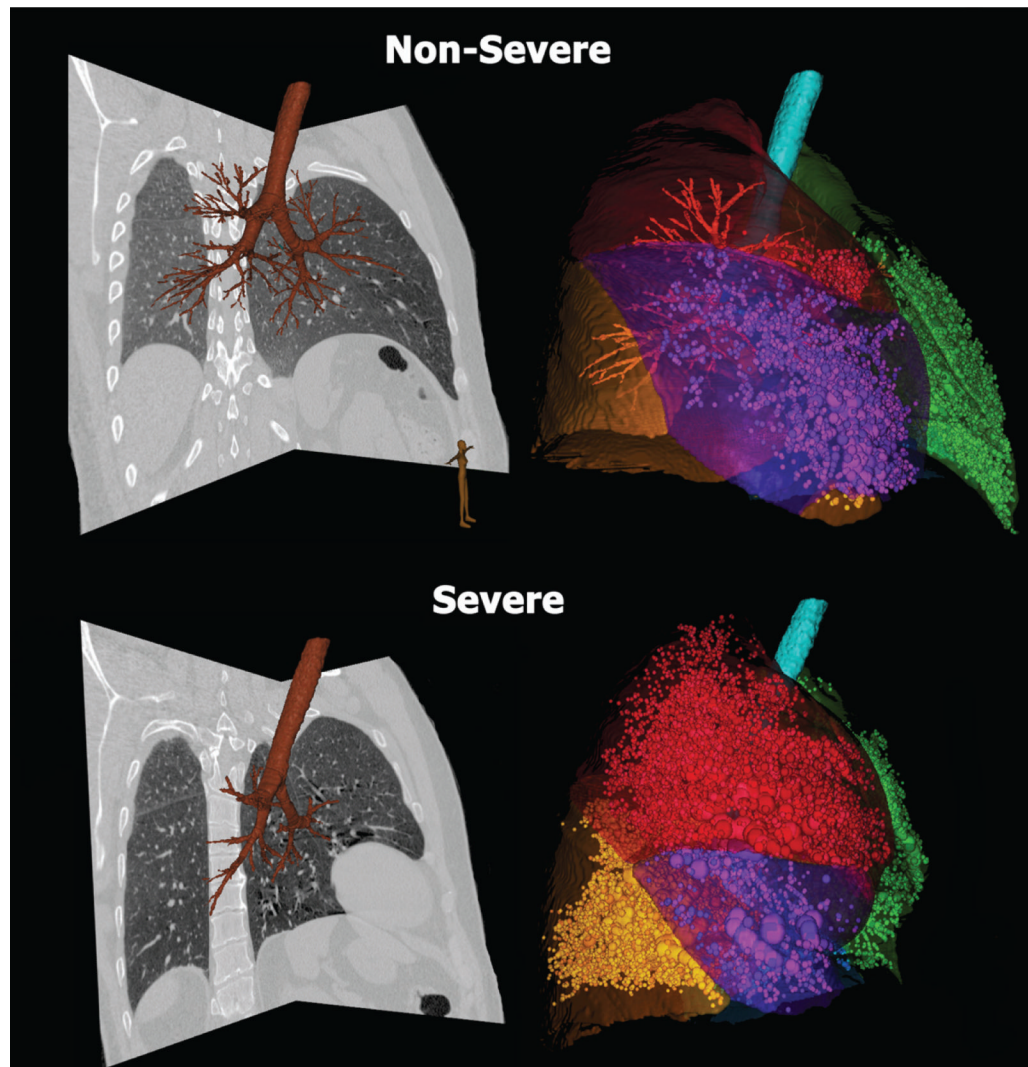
Quantitative CT of lungs in asthma
